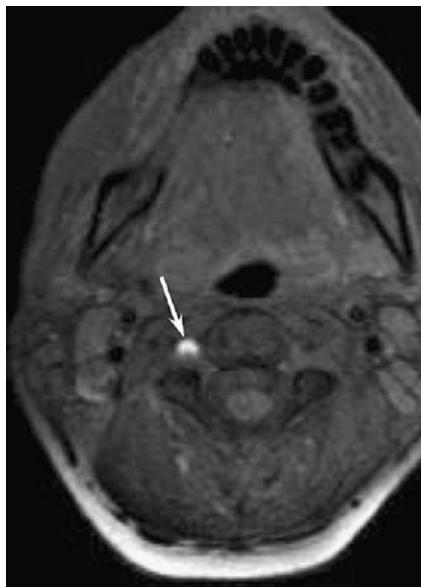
Vertebral artery dissection. Axial fat-suppressed unenhanced T1-weighted image demonstrates a crescentic focus of high signal (arrow) adjacent to the right vertebral artery. This represents methemoglobin in the false lumen of a dissection
